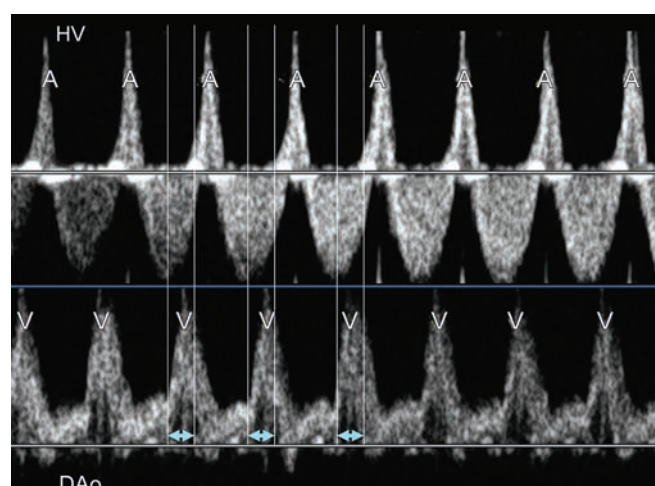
Dual Doppler recordings of the HV and DAo from a fetus with SVT. Tachycardia at a rate of 212 bpm with a 1:1 ratio of atrioventricular conduction is evident. The VA interval is shorter than the AV interval
